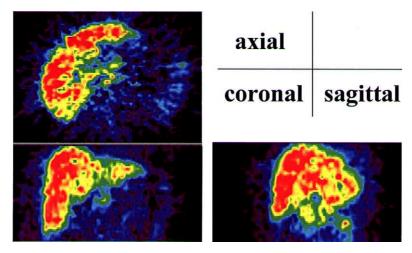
FDG-PET shows extensive diffuse abnormal accumulation throughout the whole liver (SUV 6.1).
